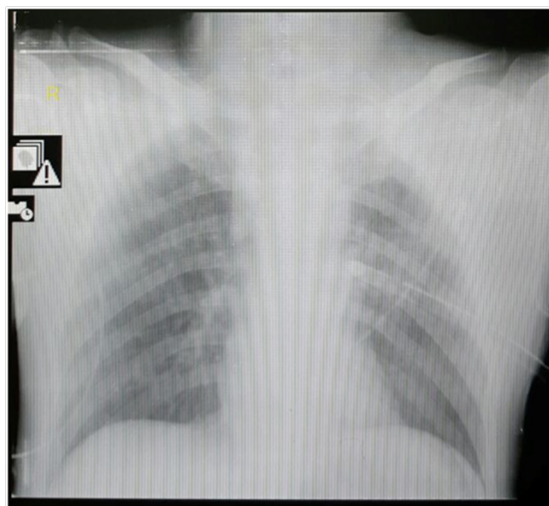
PA view chest radiograph showing fracture of both first ribs. The left 2nd and 3rd ribs including the left clavicle and left scapula are also fractured.
